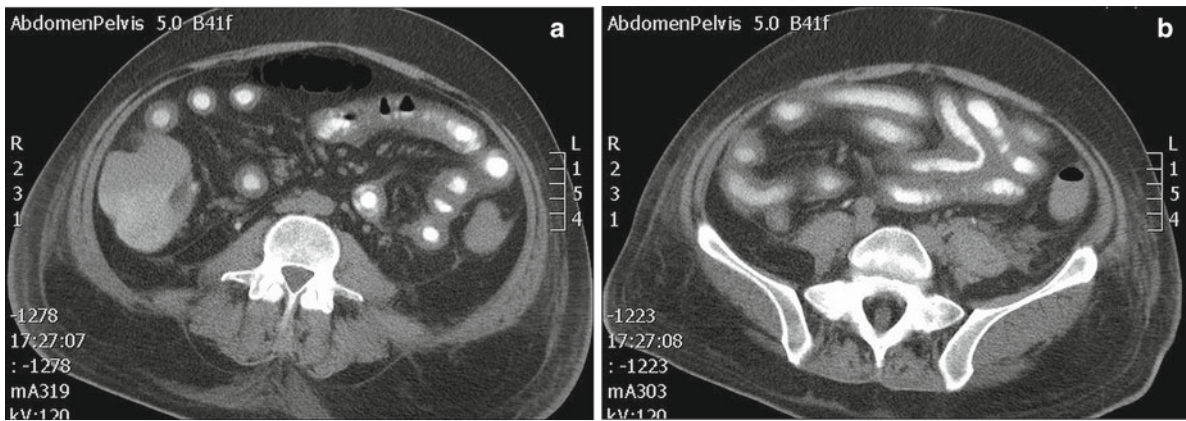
A 74-year-old woman after returning from a trip developed severe diarrhea and crampy abdominal pain. (a, b) Axial oral contrast enhanced CT images in the lower abdomen/upper pelvis level shows
